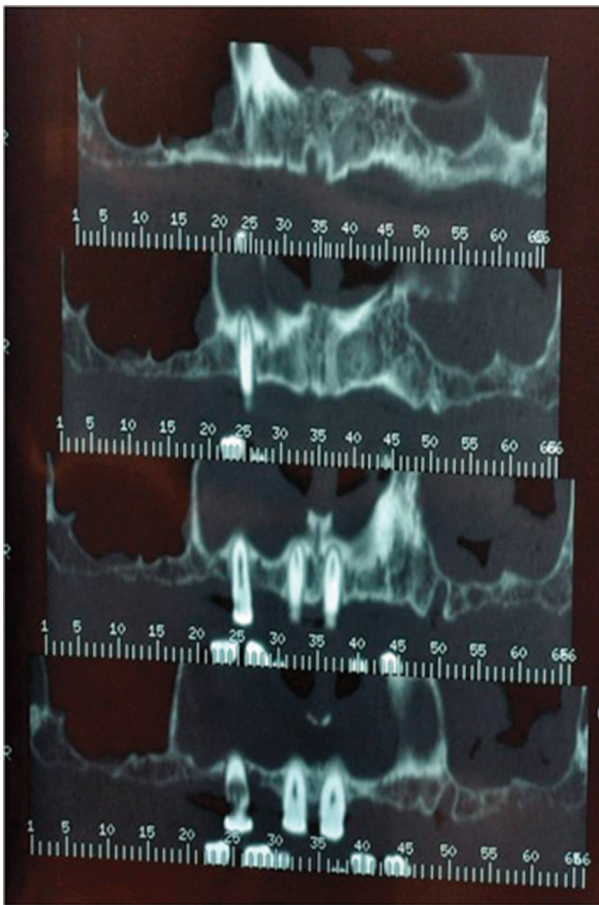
CT of the initial situation with shading of the left maxillary sinus
